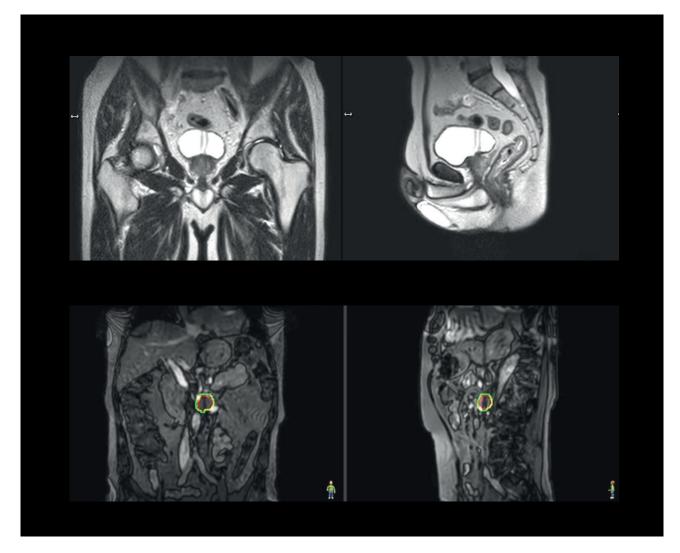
Top: Balanded cine sequence for real time monitoring of fast moving respiratory targets. Bottom: T2-weighted cine sequence for real time monitoring of the prostate. Images courtesy of UMC Utrecht.
